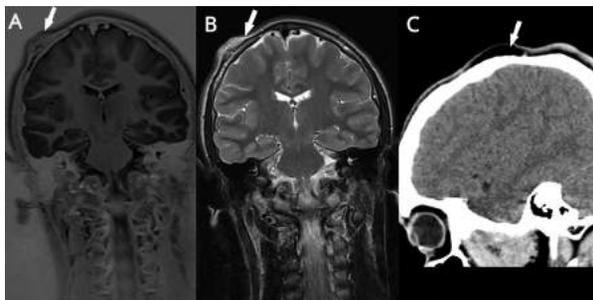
T1W (A) and T2W (B) in the coronal plane, and CT (C) in the sagittal plane; Arrows show a subcutaneous mass in the right parietooccipital region, with signal intensity and density of the fatty tissue, suggesting the presence of a subcutaneous lipoma
